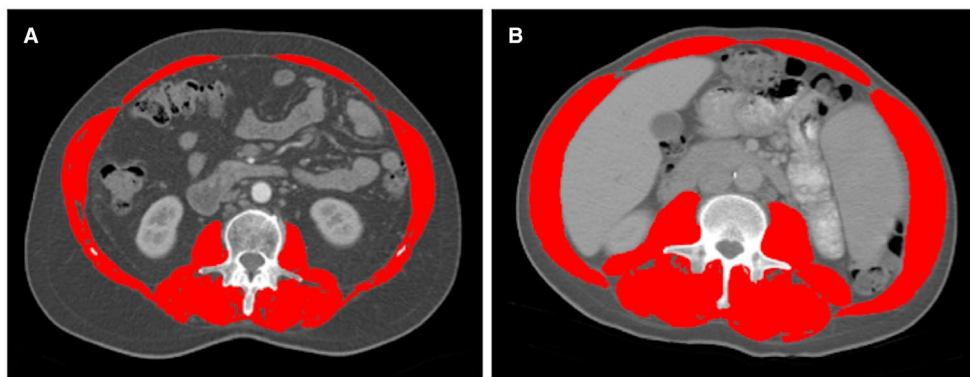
Total muscle area quantification at the level of third lumbar vertebra using abdominal CT images from two male patients with cirrhosis. (A) and (B), respectively, present a patient who had low SMI ($46 \text{ cm}^2/\text{m}^2$) and high SMI ($60 \text{ cm}^2/\text{m}^2$) as indicated by the red shading.
